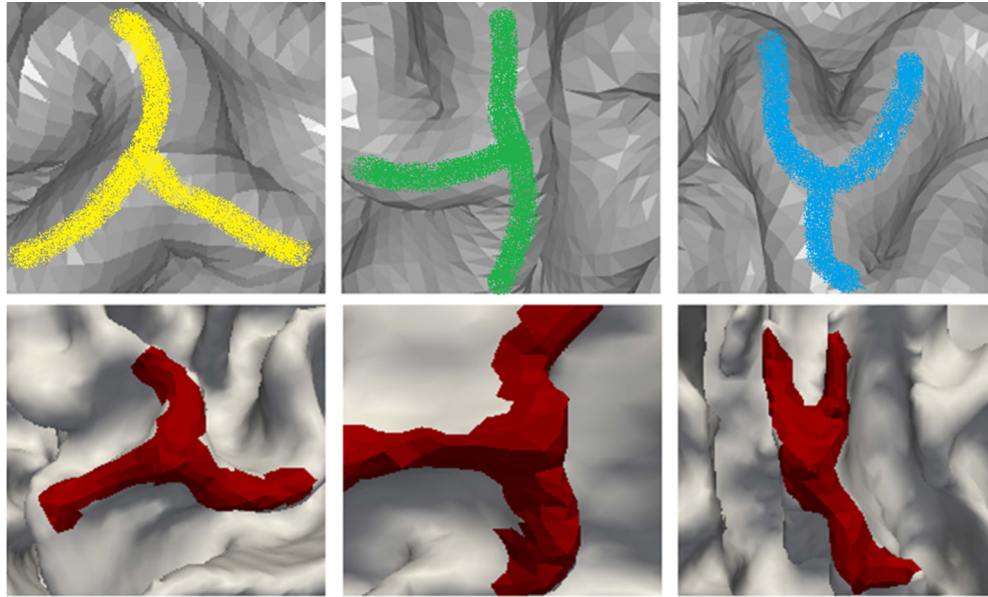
(Color online) First row: three examples of three hinges on convoluted models; second row: similar gyral folding patterns on white matter surface in real brains. Red color regions highlight the crests of gyral regions which are based on T1-weighted MRI segmentation (figures are not in the same scale).
